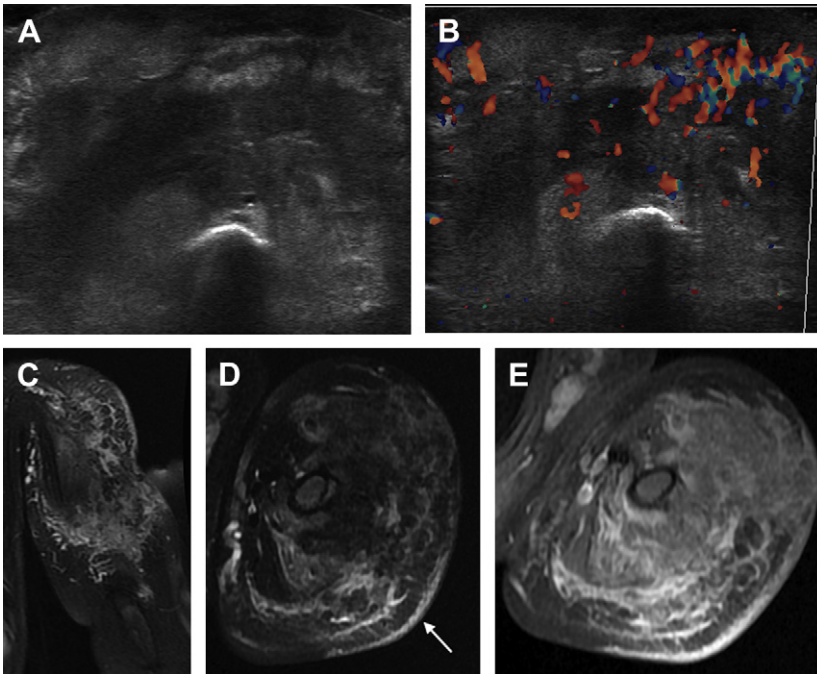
KHE in the upper left arm of an 11-month-old boy. (A) Transverse US image shows poorly defined heterogeneous soft tissue mass of the arm. (B) Color Doppler demonstrates hypervascularity. Coronal (C) and axial (D) T2 FS images demonstrate an infiltrative hyperintense lesion involving multiple tissue planes, with areas of skin thickening (arrow). (E) Axial T1 FS postcontrast images show heterogeneous enhancement.
